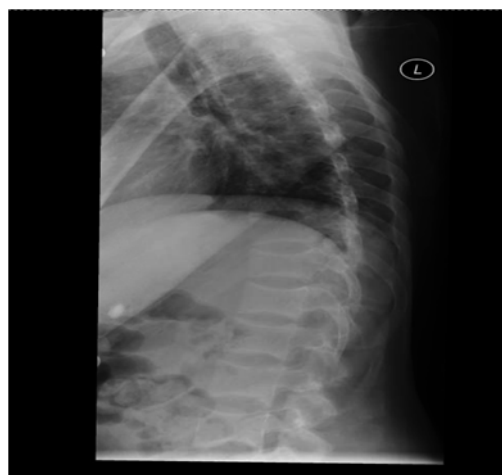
X-Ray of Thoracolumbar spine showing "Fish Vertebrae" suggestive of compression fractures.
